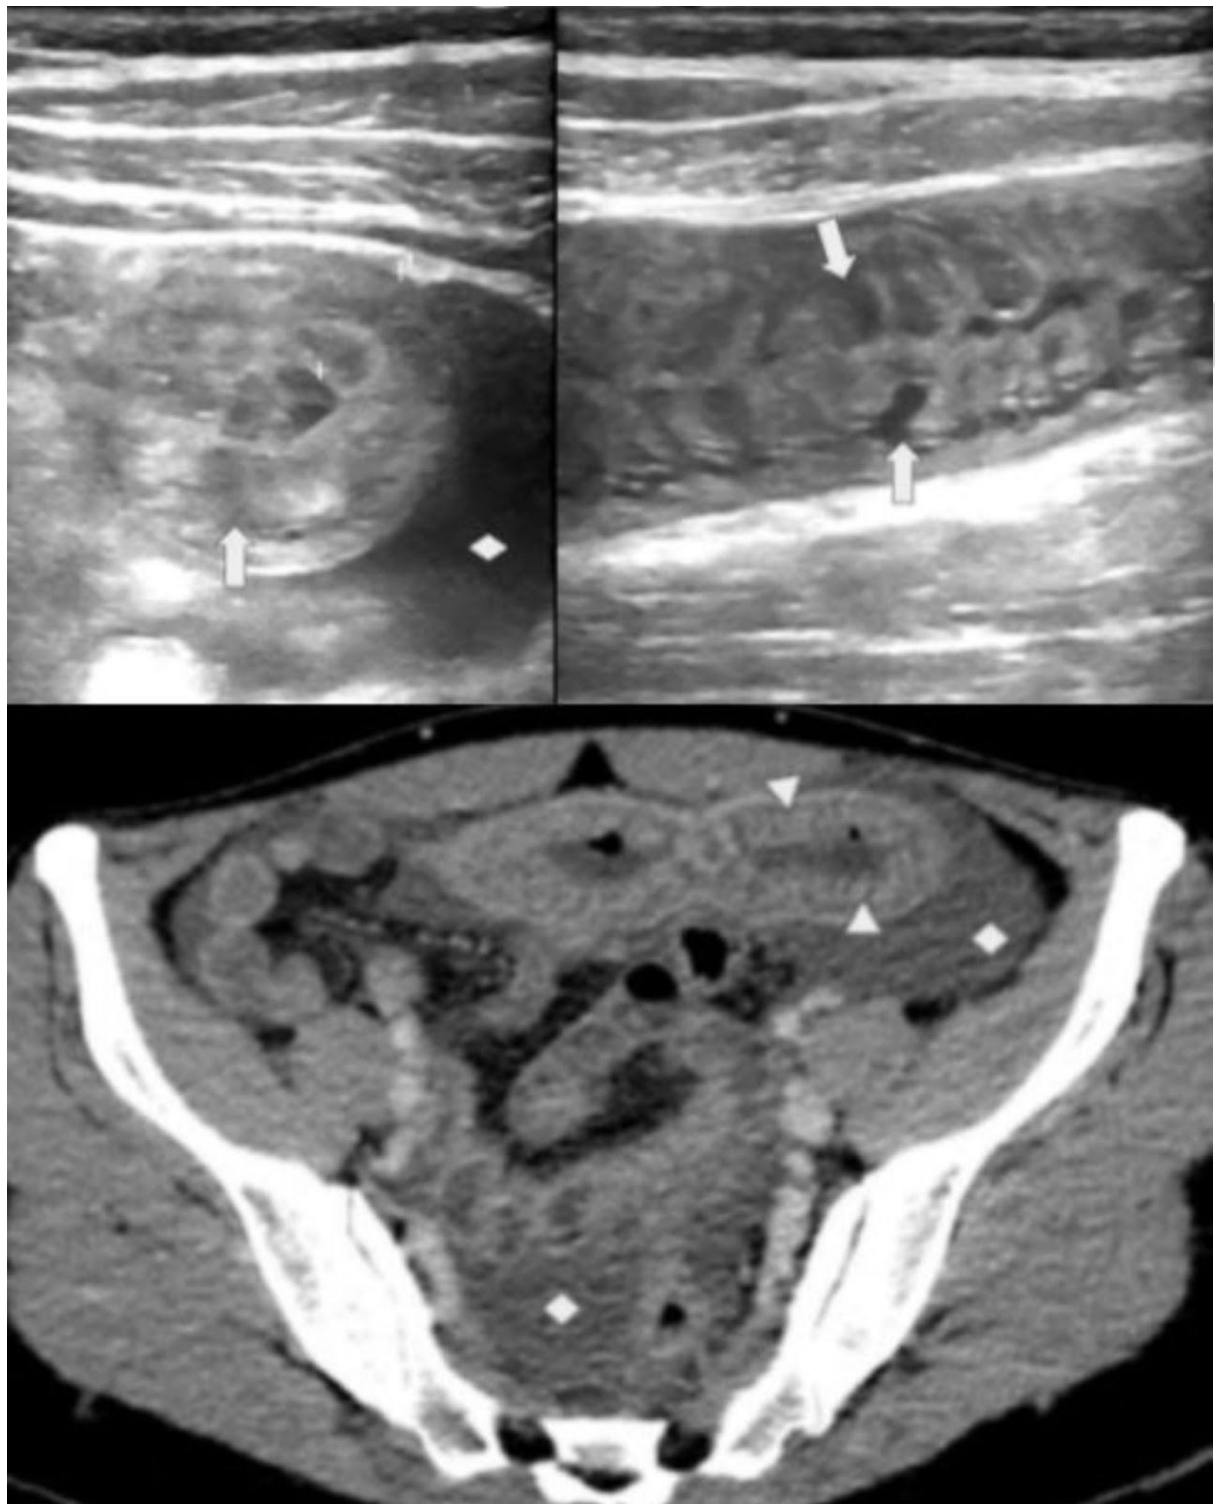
Ultrasound abdominal examination (image above) at hypogastrium shows a large ileum segment with wall thickening and marked submucosal edema (arrows), preserving its normal layer pattern.
